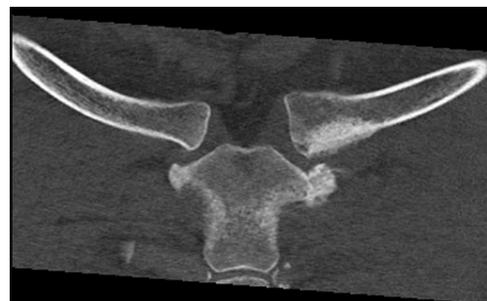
Postoperative computed tomography scan showing increased costoclavicular interval with excision of ledge of bone superior to first rib.
